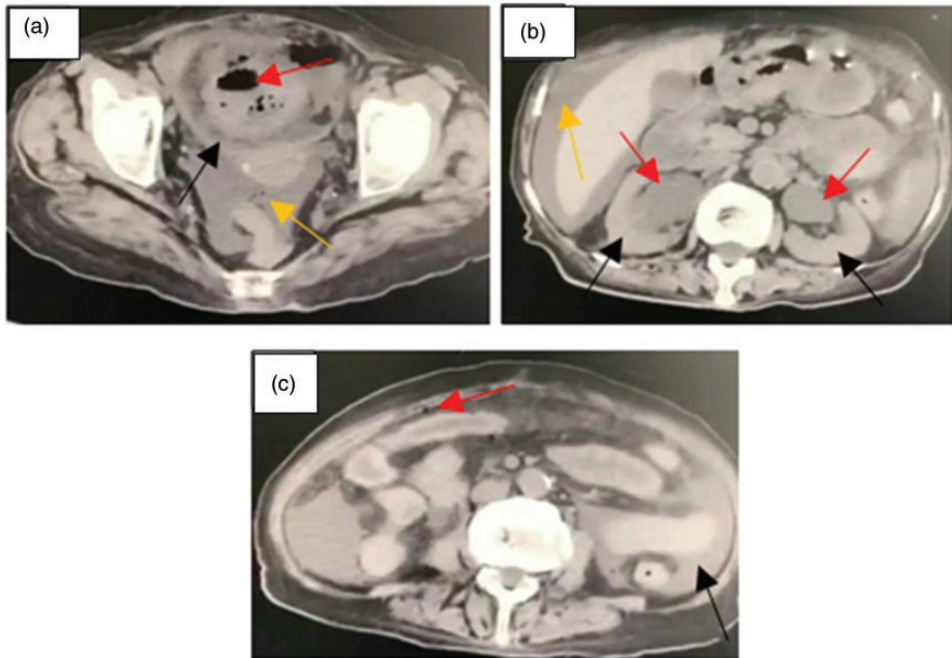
Computed tomography manifestations of emphysematous cystitis complicated by double ureteral dilatation and double kidney atrophy in an 80-year-old female patient that presented with abdominal pain, fever, dysuria, urinary urgency, urinary frequency and urinary retention. (a) The bladder wall was significantly thickened and liquid density was visible inside (black arrow). More gas could be seen in the bladder cavity (red arrow) and a large amount of exudate could be seen around the bladder (yellow arrow). (b) There was bilateral ureter dilatation (red arrow), bilateral kidney atrophy (black arrow) and more fluid could be seen in the abdominal cavity (yellow arrow). (c) The density of the liquid (black arrow) and gas (red arrow) could be seen in the abdominal cavity. The colour version of this figure is available at: <http://imr.sagepub.com>.
